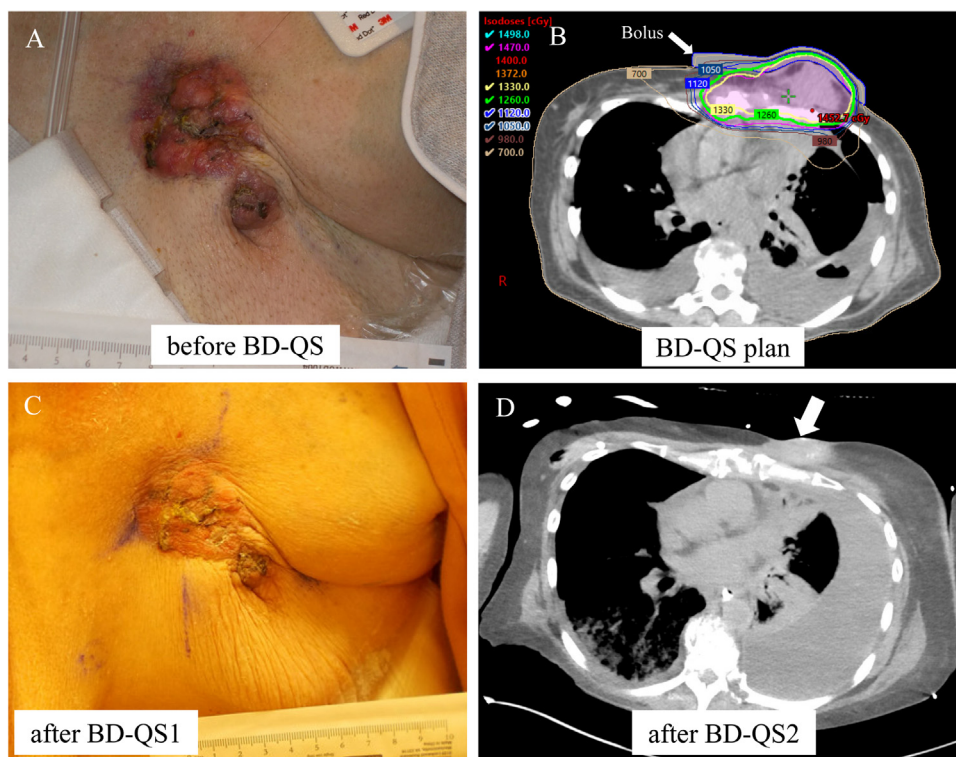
(A) Fungating mass from neglected breast cancer in left breast causing intractable pain whenever she breath or cough in case 2; (B) Radiation therapy plan for BD-QS1; (C) left breast lesion at 3 weeks after BD-QS1; (D) Computed tomography scan of the chest showing left breast lesion at 2 months after BD-QS1 (white arrow). *Abbreviation:* BD-QS = breast-directed quad shot.
